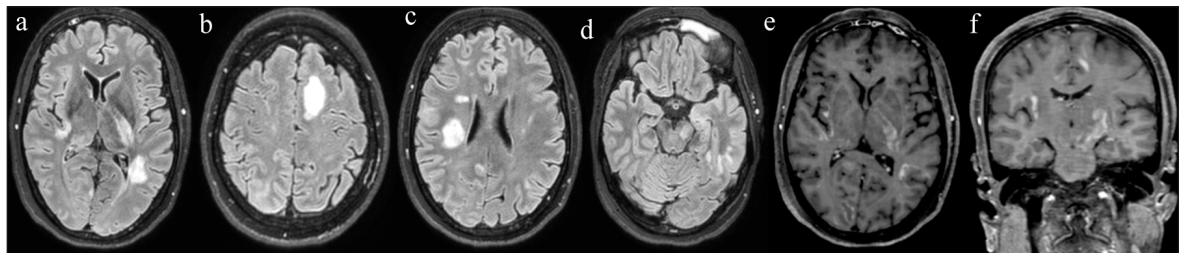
Initial brain MRI (a-d: axial T2-weighted-fluid-attenuated inversion recovery (FLAIR) images; e-f: axial and coronal post-contrast T1-weighted images) demonstrating multifocal T2 hyperintensities involving the bilateral and supratentorial white matter (a-d), heterogeneously enhancing (e-f). The affected left amygdala and hippocampus head, as well as the thalamic-mesencephalic transition can also be seen (d).
